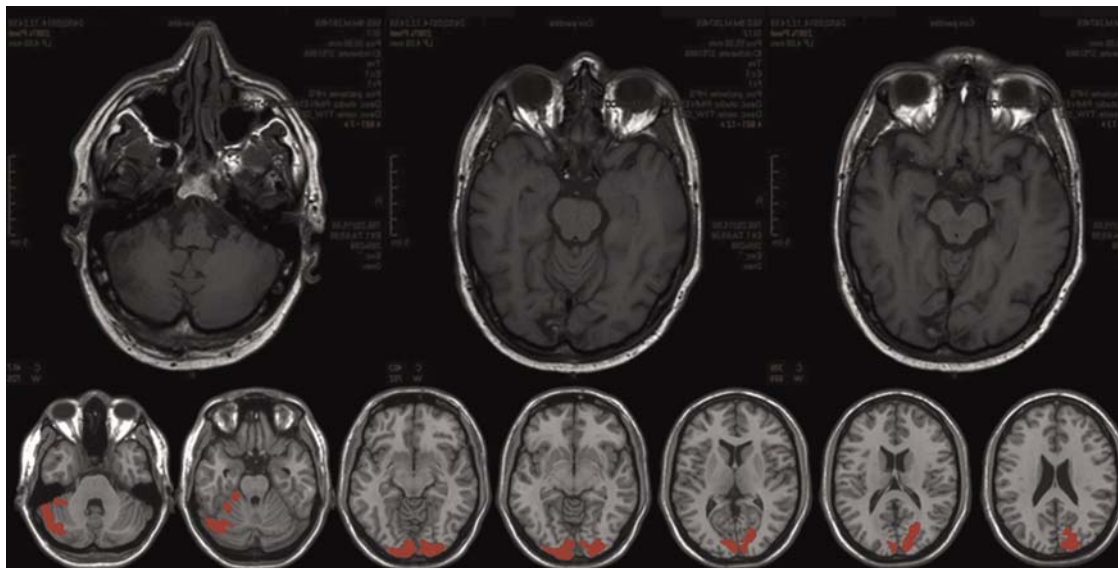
Images of the brain: 2010s. MRI image of a patient with abnormalities of visuo-motor plasticity in adaptation to prisms displacing the visual scene: bilateral occipital and left cerebellar lesions (Calzolari et al., 2015, Fig. 1).
